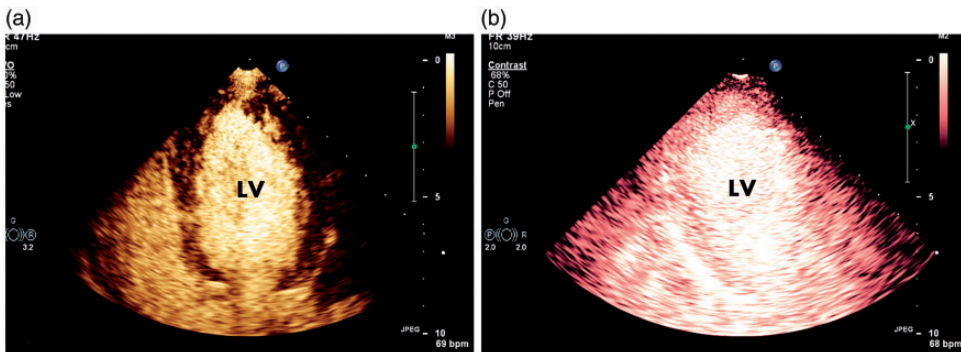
(a) Left ventricular opacification demonstrates smooth endocardial boundaries with good left ventricular filling and no filling defects. (b) Myocardial contrast echocardiography shows no abnormalities. LV, left ventricle.
